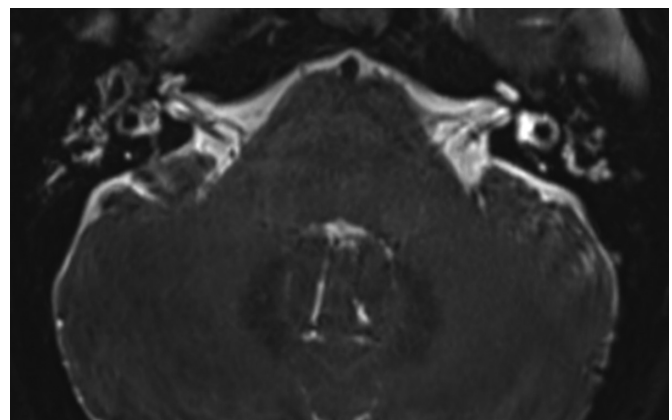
Axial heavily T2-weighted magnetic resonance image of the labyrinth shows a decreased T2 signal intensity of the fluid in the right-sided cochlea, vestibulum, and semicircular canals.
